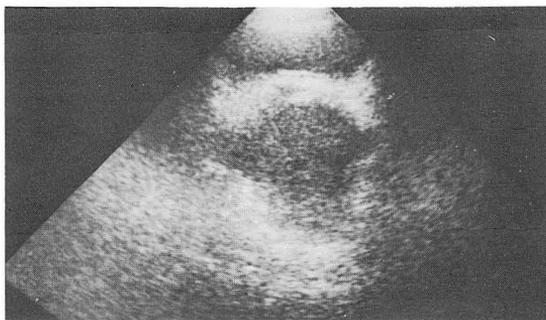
Ultrasonographic findings : Asymmetrical enlarged prostate with inhomogeneous internal echo-texture in entire prostate.
